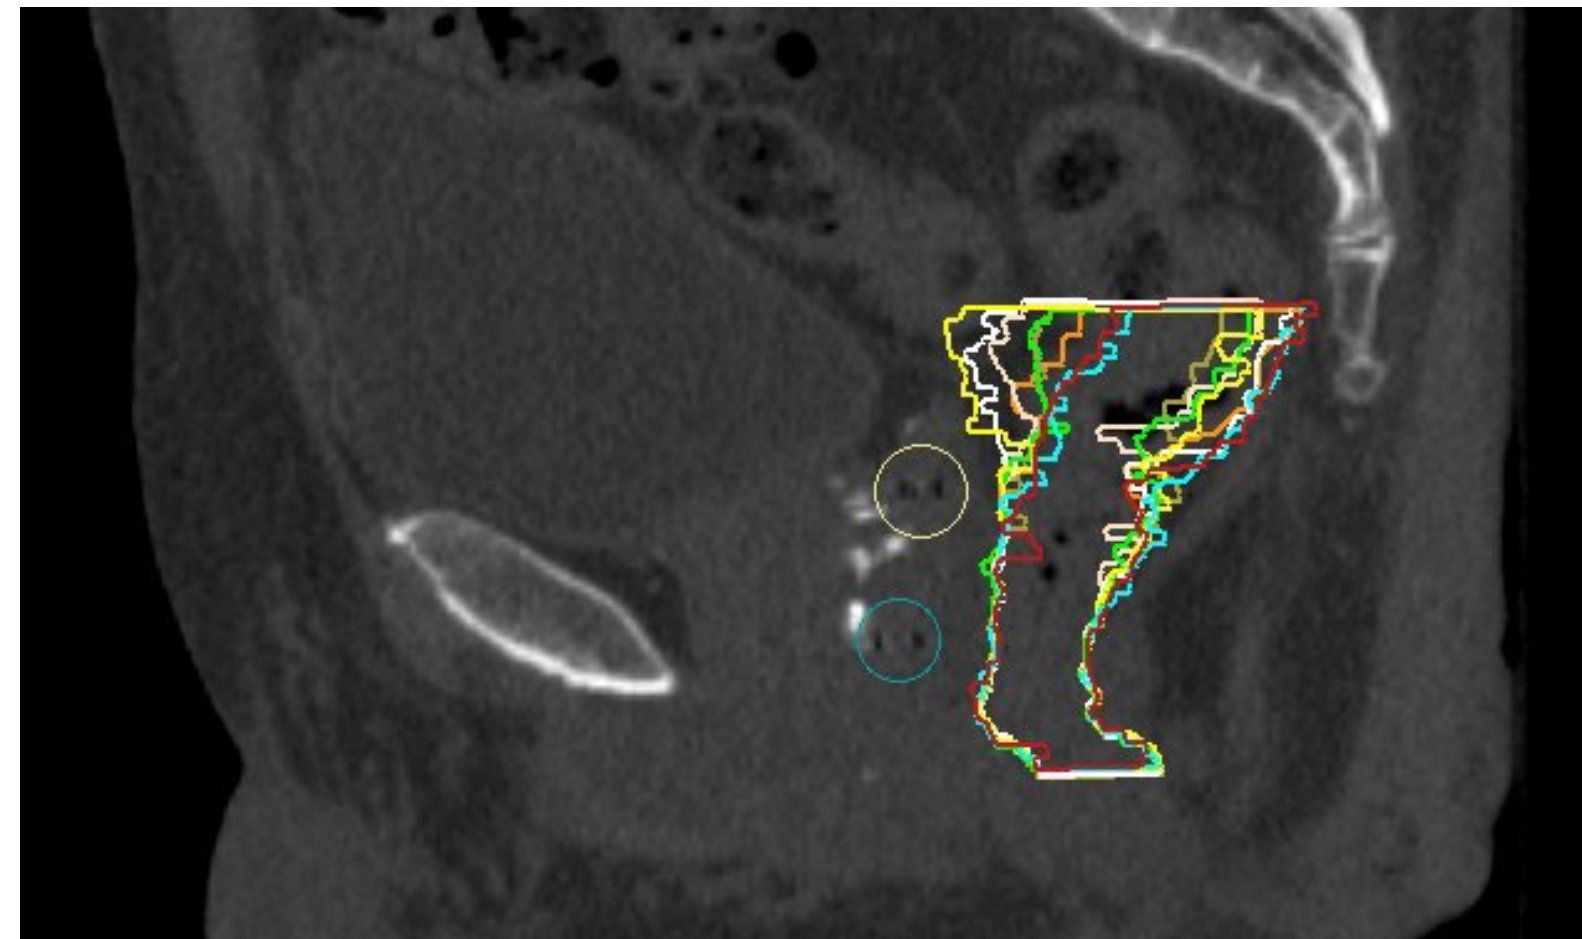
Rectum volumes. Rectal contours for each treatment CBCT.
